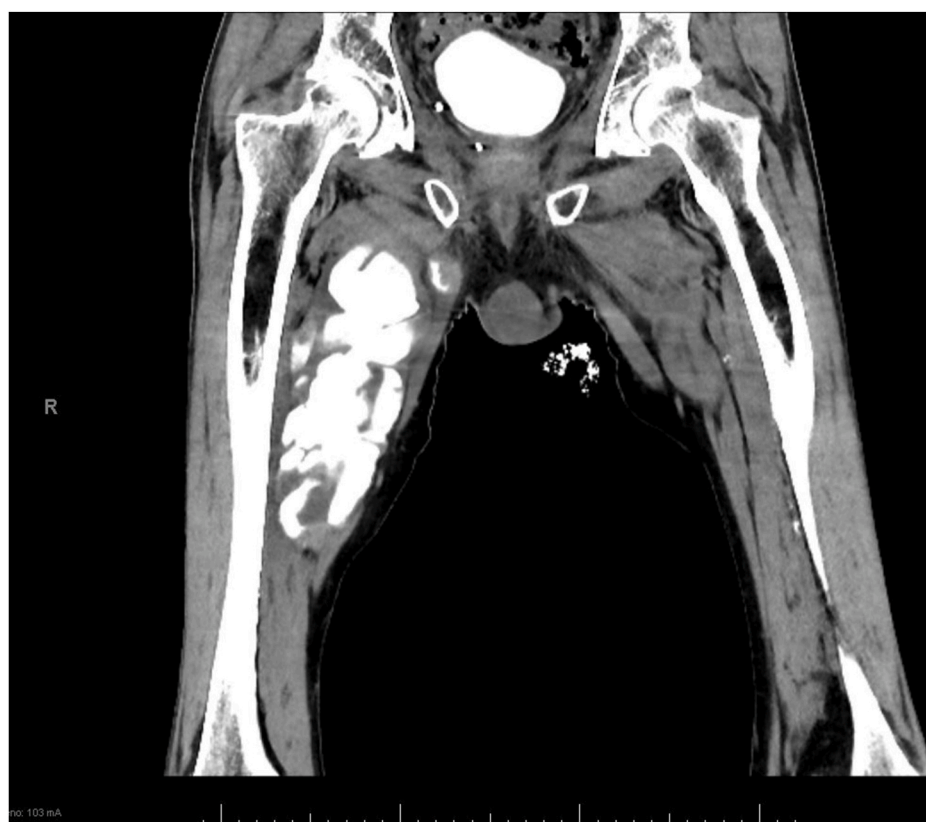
Computed Tomography scan shows a fluid collection from the pelvis to the right inner thigh.
